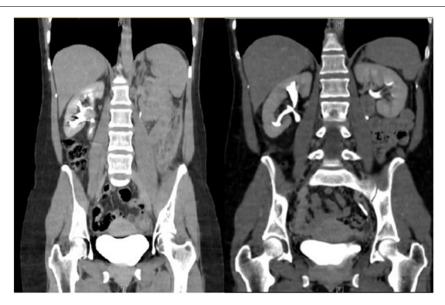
On the left side, CT scan with contrast-enhanced lesion in right renal pelvis; measuring $20 \times 23 \times 25$ mm. On the right side, control CT scan six months after surgery.
